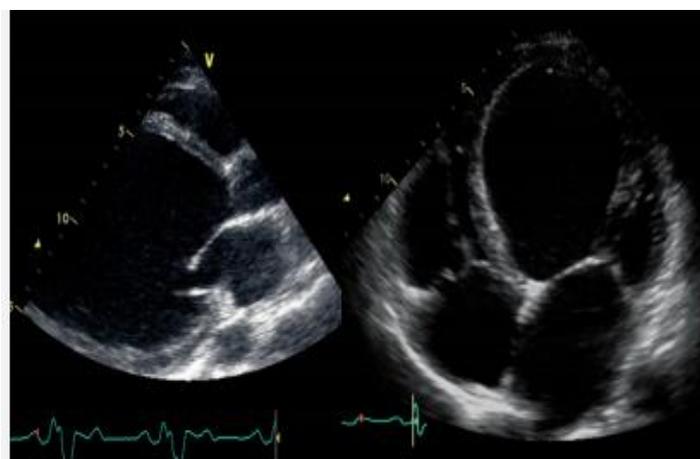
Echocardiography revealing a dilated cardiomyopathy
